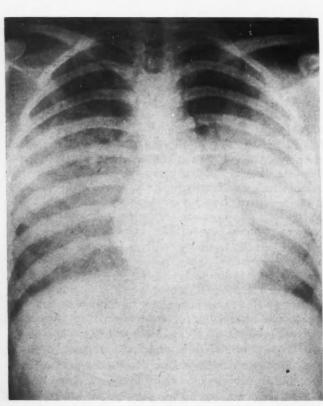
December 4, 1958. No apparent change since the first radiograph, but the technique used is different. This overpenetrated radiograph shows some calcified lymph nodes in the left hilum.
